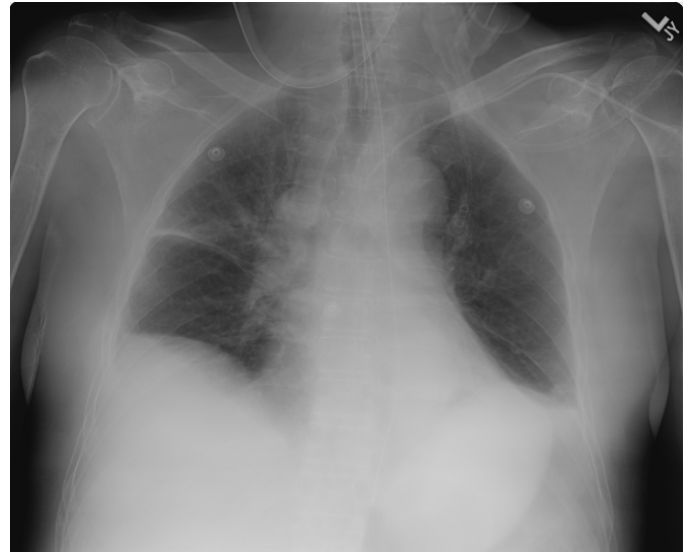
Chest radiograph from hospital day one shows lungs that are adequately inflated with bilateral costophrenic angle blunting representing small pleural effusions. Right lung fissure thickening represents fluid.
